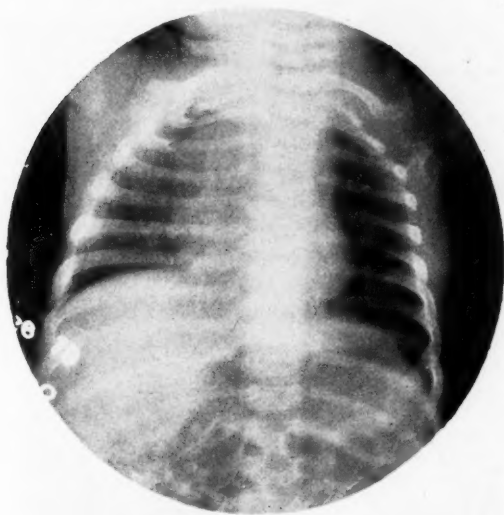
Case 290922. B. G. M., a girl aged four months. Angioma of the left labium. Tentative diagnosis of malignant tumor. x-Ray for metastasis showed enlarged thymus, but no metastasis.
